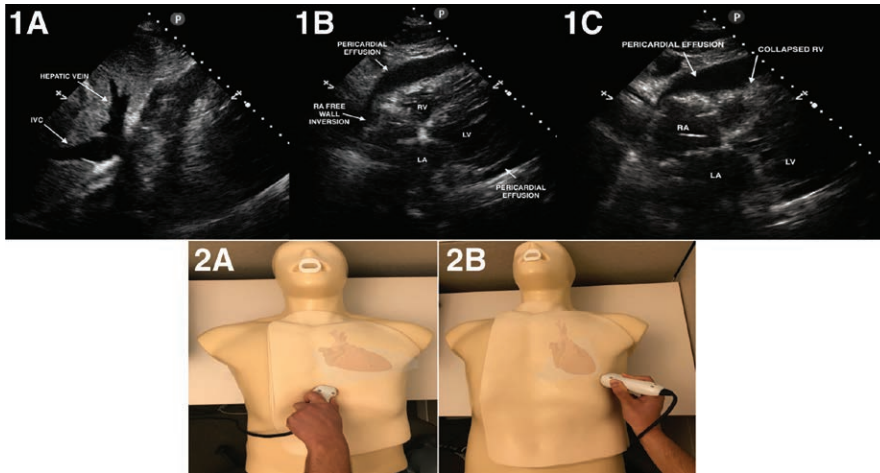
Images in Anesthesiology: Early Identification of Tamponade Using Focused Cardiac Ultrasound
